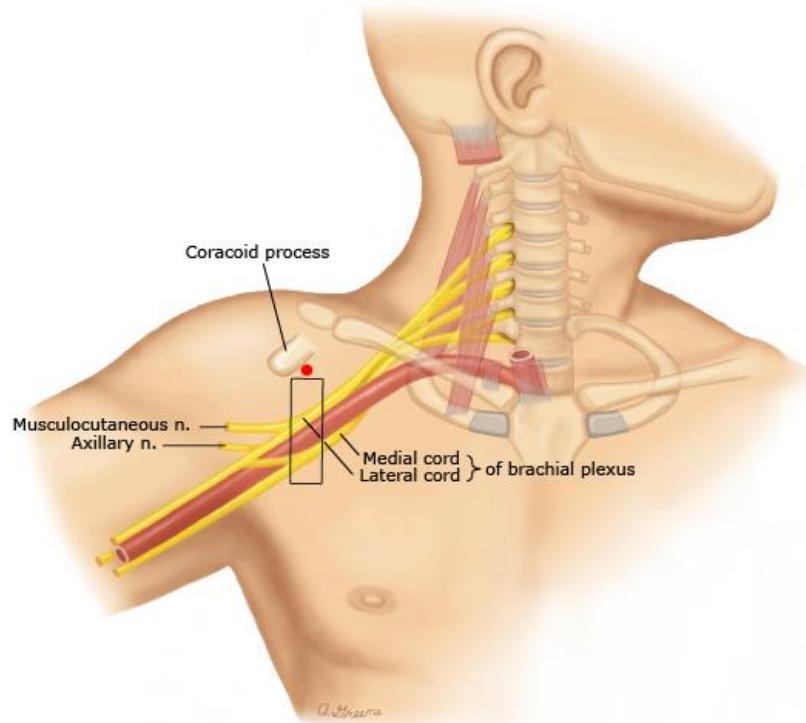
Infraclavicular brachial plexus block guided by ultrasound
